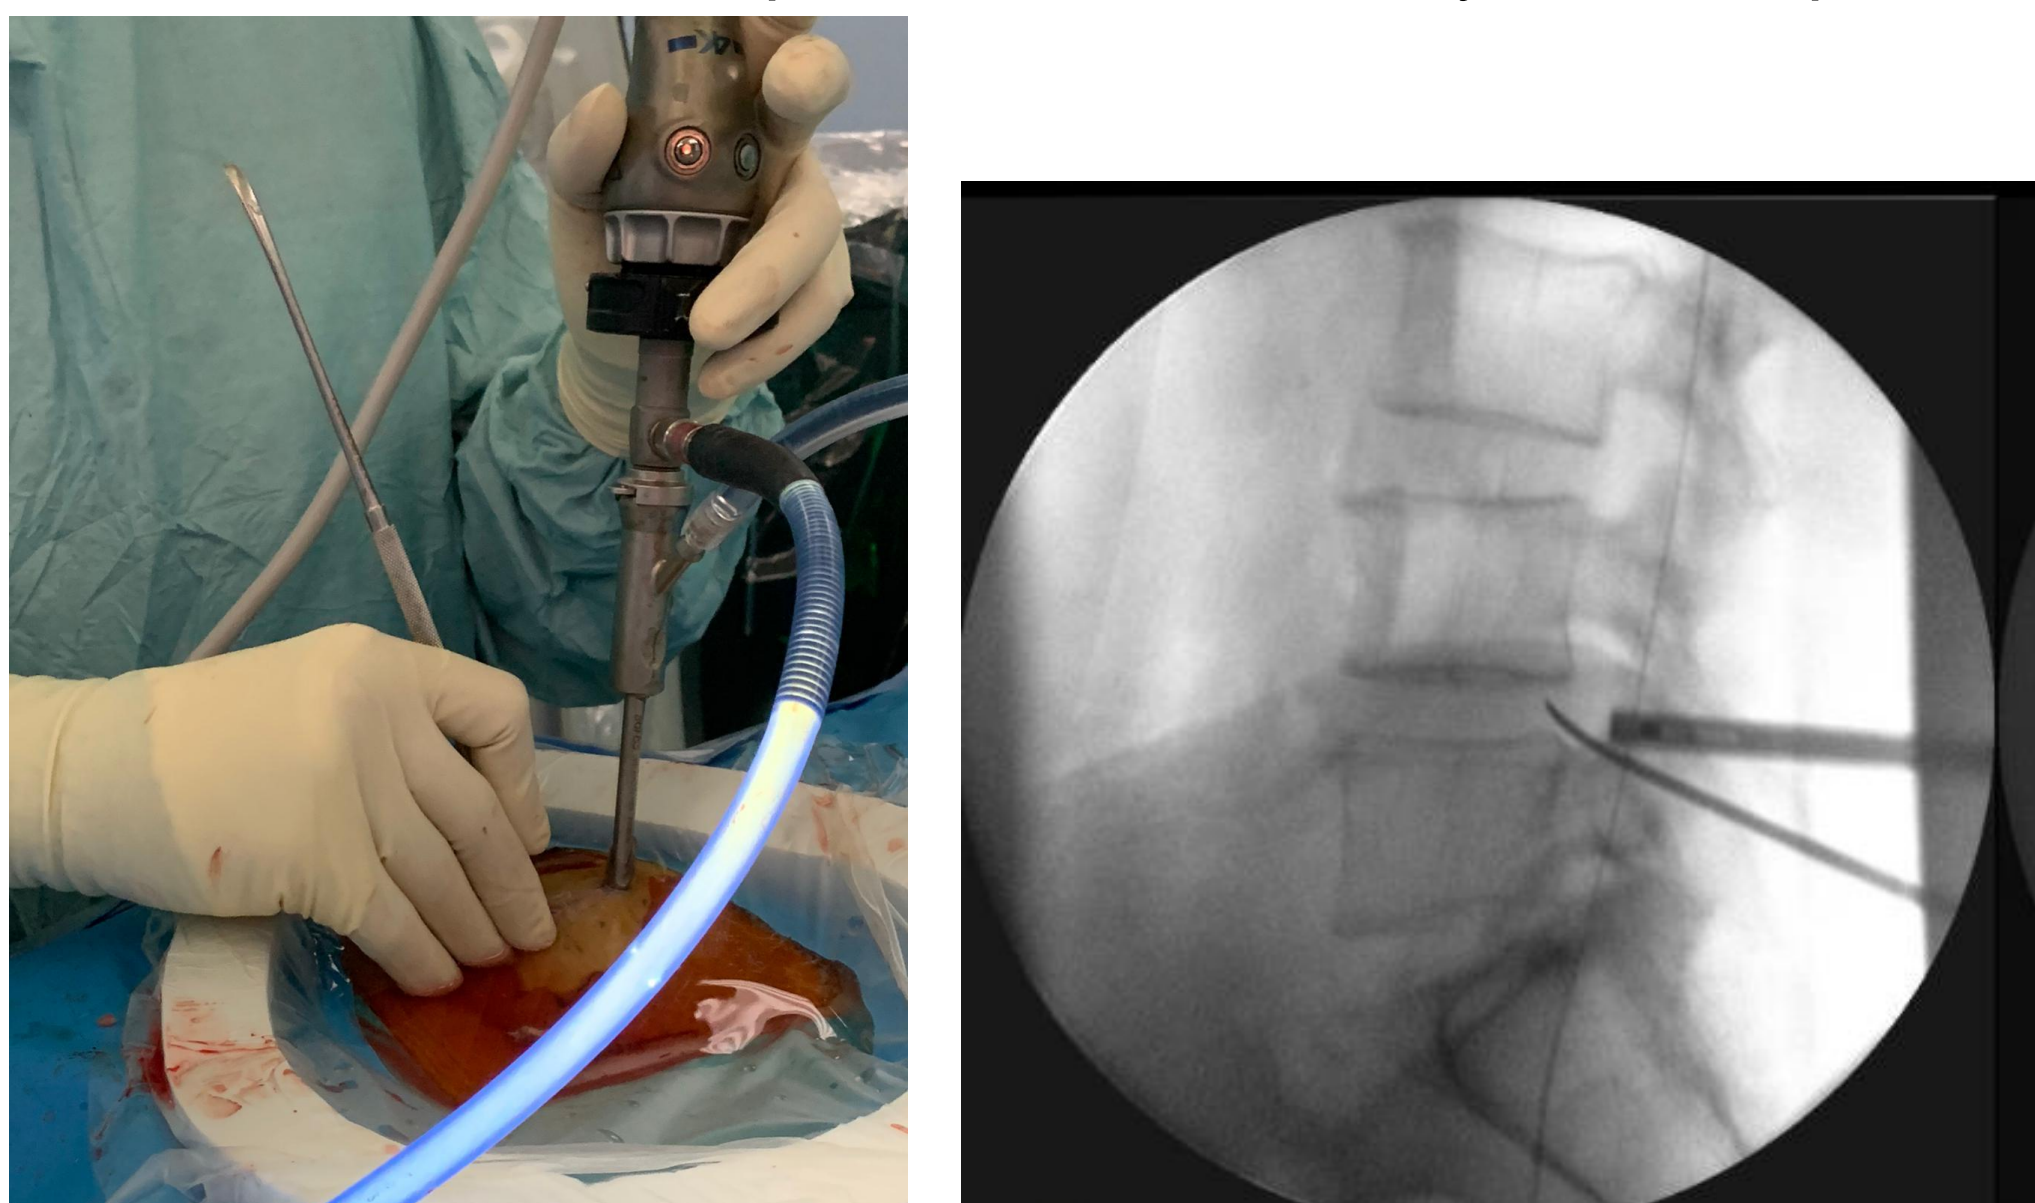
shows (top-left) pen-field dissector and 0-degree endoscopic usage through two incisions, (top-right) lateral radiograph shows dissector at L4-5 disc space, (bottom-right) lateral radiograph shows decompression from L3 pedicle to L4 pedicle, (bottom-left) endoscopic view of disc retrieval via nerve root axilla.
